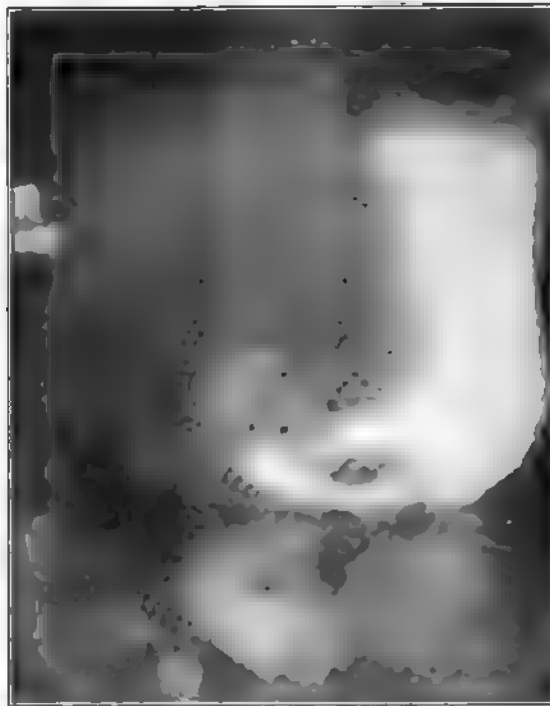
(Case No. A86,058, X-ray No. 22,260.) Male, aged forty. Filling defect pars media and pylorica. No residue after six hours. Pylorus gaping. Exploration: Carcinoma of the stomach.
